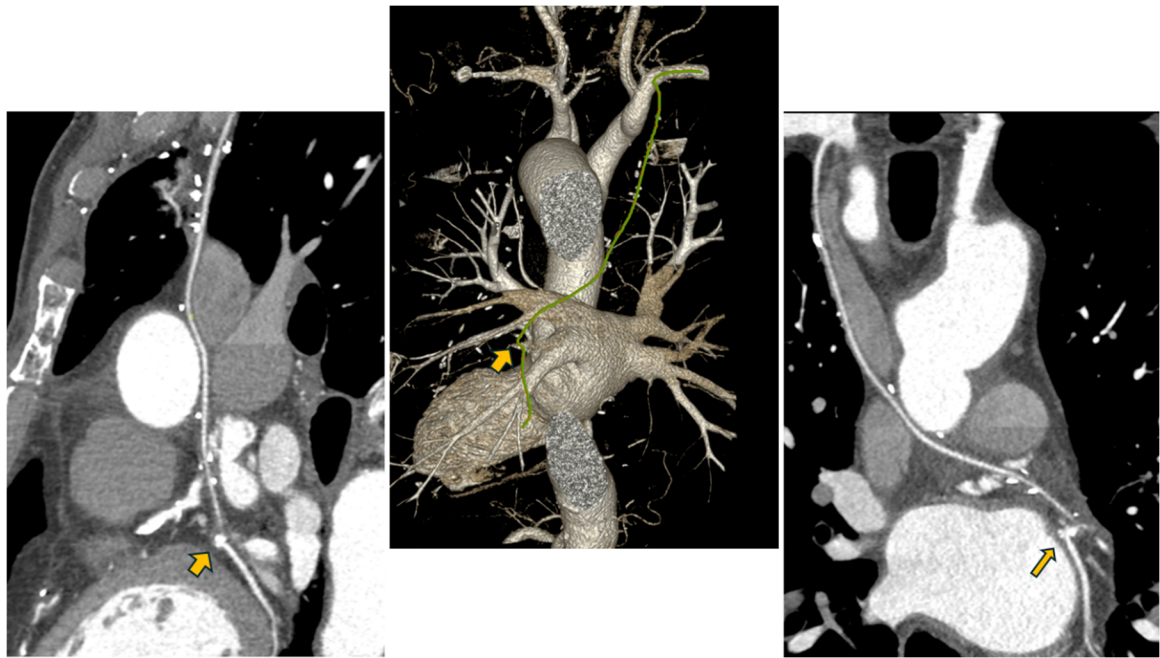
Post-operative computed tomography assessment of the RITA-Circumflex artery direct vascularization one year after surgery. Left: Sagittal thoracic CT slice demonstrating patency of the circumflex coronary artery. Middle: Three-dimensional volume-rendered reconstruction highlighting the retro-aortic course of the RITA, with an unobstructed trajectory, absence of kinking, and the characteristic "cobra head" anastomotic configuration. Right: Retro-aortic pathway of the RITA, anastomosed to the circumflex artery at the site indicated by the arrow.
